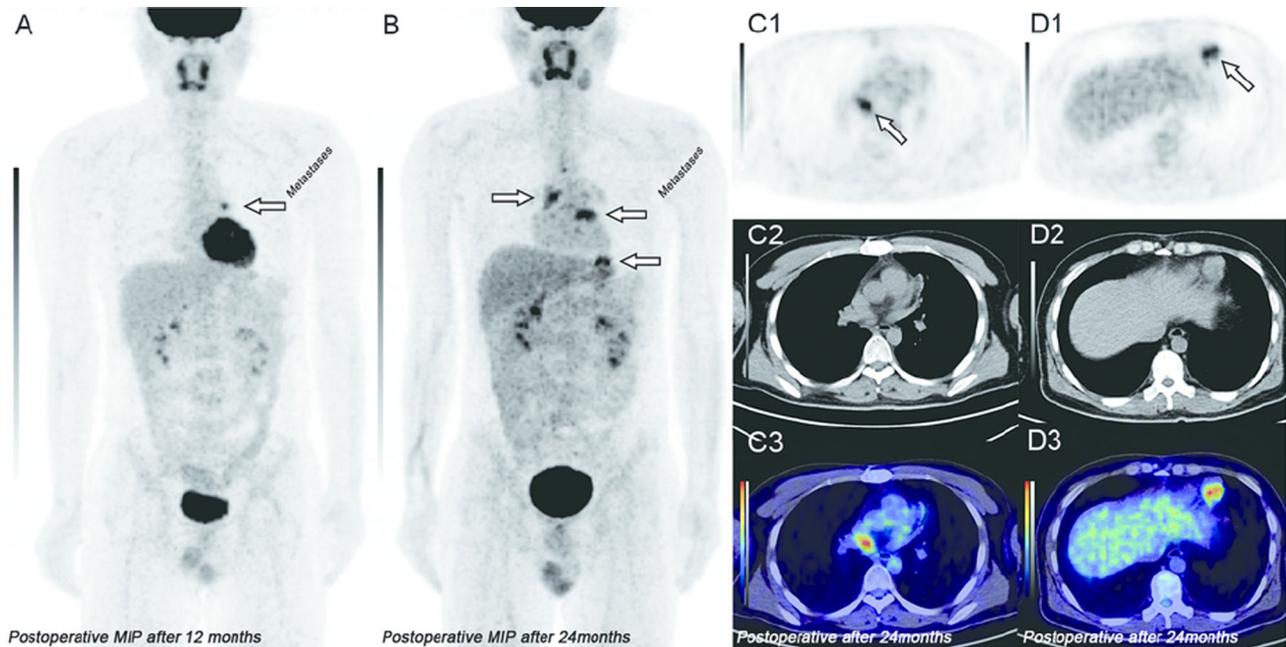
Postoperative follow-up 18F-FDG positron emission tomography combined with computed tomography imaging. A MIP image at 12 months after surgical resection showing a metastatic nodule adjacent to the root of the pulmonary trunk (white arrow, SUVmax 3.6). B MIP image at 24 months after surgical resection showing multiple metastases in the mediastinum and pericardial cavity (white arrow, SUVmax 4.3). C and D Transverse view of the selected PET (1), CT (2), and fused PET/CT (3) images showing that the metastatic foci were located in the mediastinum and pericardium, respectively.
